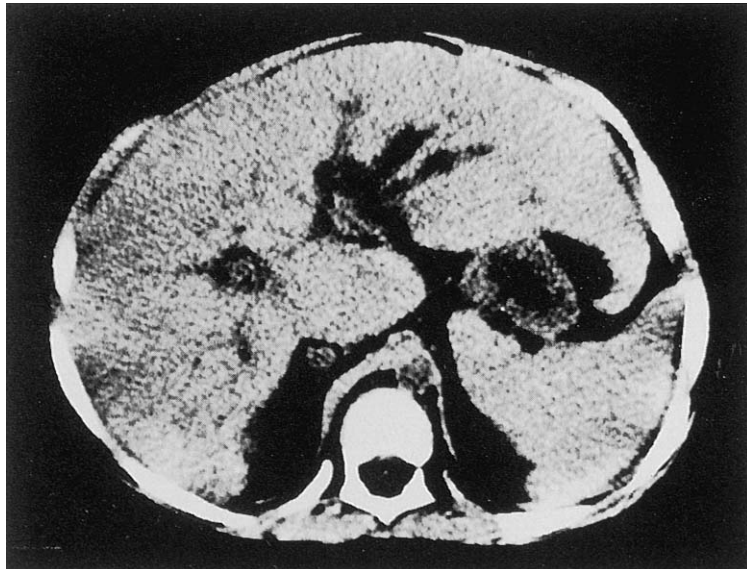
CT scan of the liver of Case 6.
